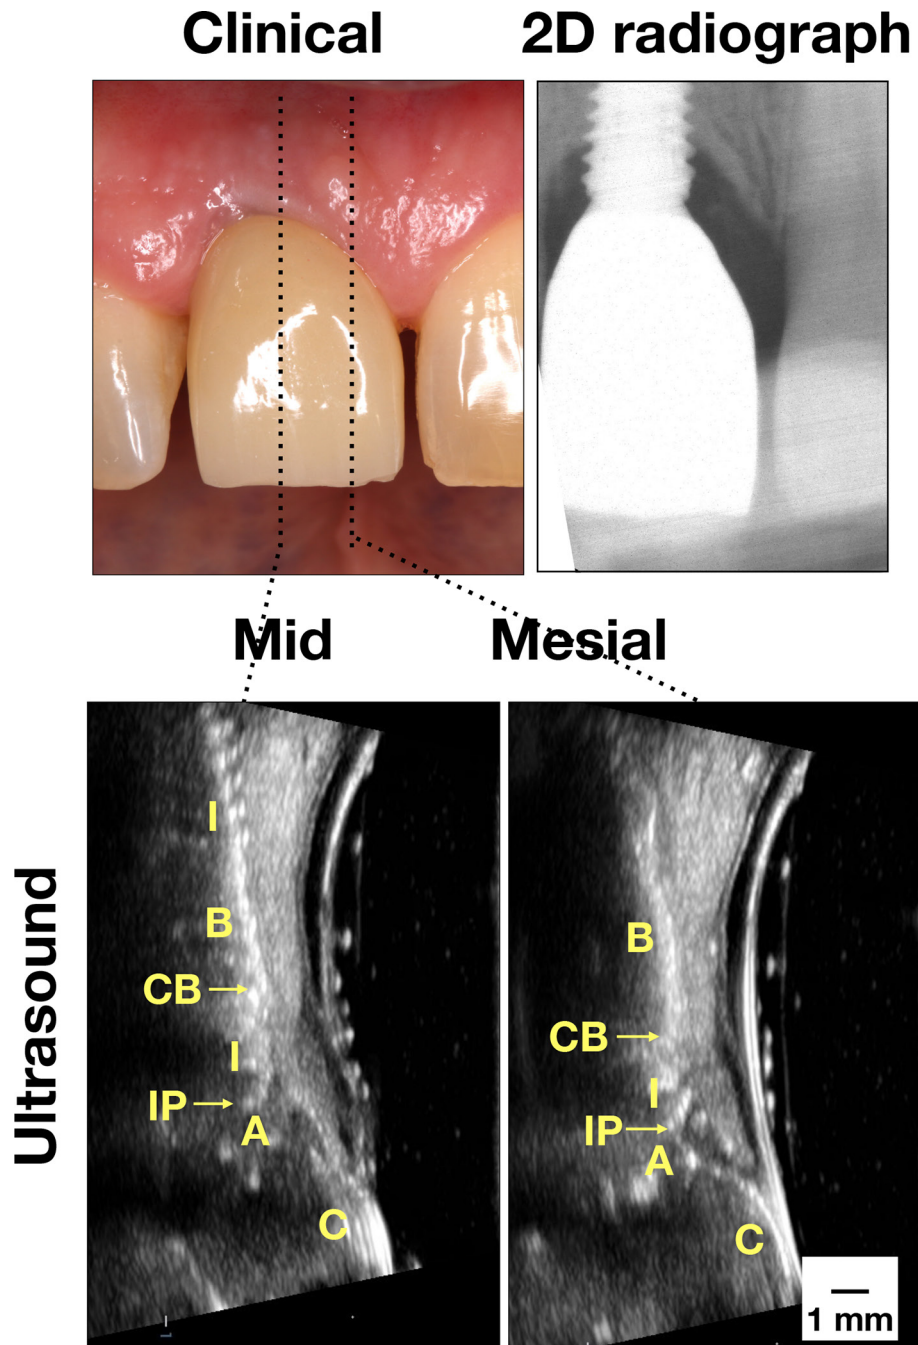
Case demonstration of an implant with hard and soft tissue deficiency. Clinically, there was slight inflammation. Some bone loss was found on the peri-apical film. Ultrasound images clearly showed thin mucosa and crestal bone, indicative of tissue deficiency. Implant exposure on the mid-facial view was evident. 2D, two-dimensional; *A*, abutment; *B*, bone; *C*, crown; *CB*, crestal bone; *I*, implant; *IP*, implant platform; *M*, mucosa; *p*, papilla.
